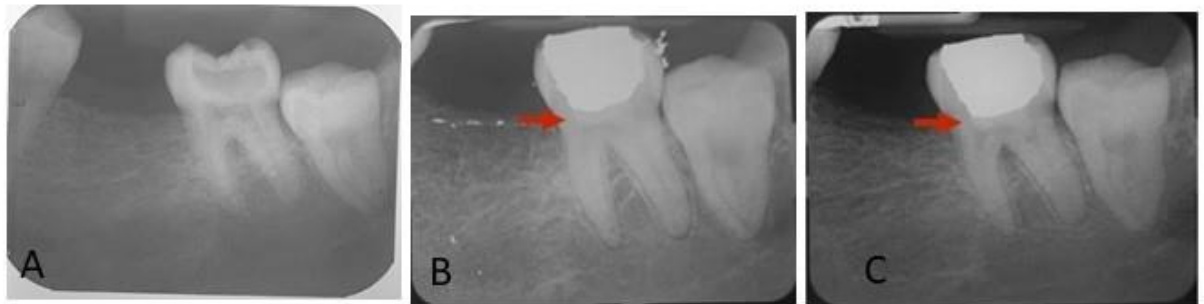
Radiographs of 25-year old female patient with signs and symptoms clinically suggestive of irreversible pulpitis and normal periapex in tooth 48. A: Preoperative radiograph, B: Immediate postoperative radiograph after full pulpotomy using Biodentine, C:3-year recall showing normal periapex.
